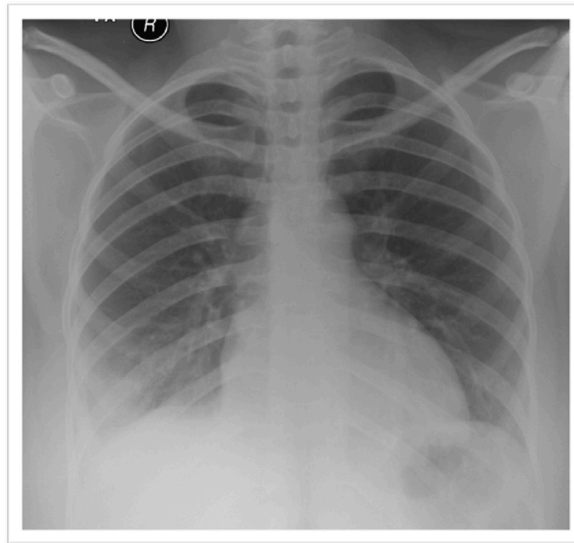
(Follow up x-ray on week 2.).
